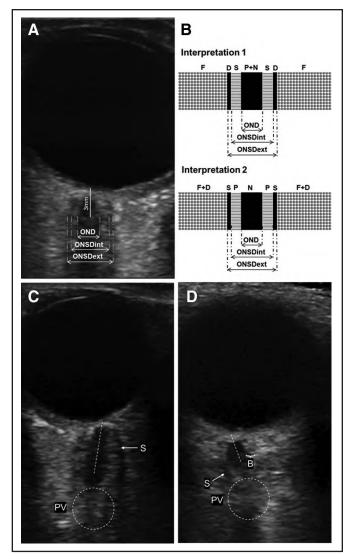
Sample images with optic nerve sheath diameter (ONSD) internal and ONSD external measurements in addition to common ultrasound artifacts that affect ONSD measurement. A, Sample image with clear anatomic differentiation for measurement of both ONSD internal (ONSDint) and ONSD external (ONSDext). B, Different anatomic interpretations in the literature. C and D, Examples of common ONSD artifacts. Partial volume artifacts (PVs) (slice thickness or volume averaging artifacts), occur when ultrasound beam simultaneously samples multiple tissues with different acoustic properties causing a "filling-in" effect. Attenuation artifacts are shadowing or enhancement of anatomic structures due to ultrasound beam path. Shadowing occurs if beam path contains strongly attenuating structures like the optic disk resulting in a darker shadow behind the eye. Enhancement occurs when ultrasound beam path crosses weakly attenuating structures like the vitreous fluid resulting in brighter structures behind the eye. Blurred boundaries can happen due to volume averaging, attenuation, or a combination of both. Artifacts are avoided by imaging in line with optic nerve and observing consistent anatomic structures that do not change in appearance as the probe moves. B = blurred boundaries, D = dura, F = fat, N = nerve, OND = optic nerve diameter, P = pia, S = shadowing, S = subarachnoid space.
